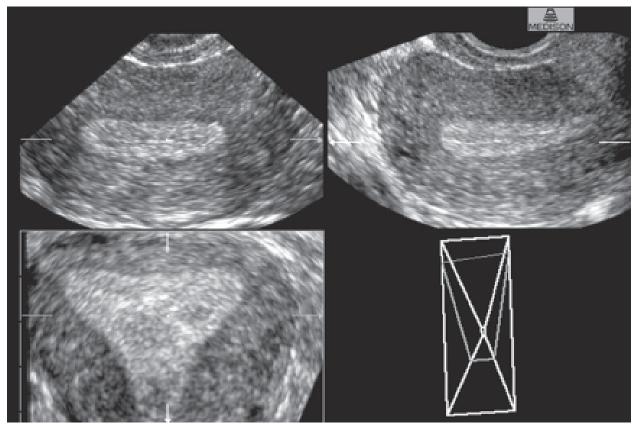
Three-dimensional ultrasound of the normal uterine cavity. Note secretory appearance of the endometrium and triangular shape of the uterine cavity in frontal reformatted section (low left image)
